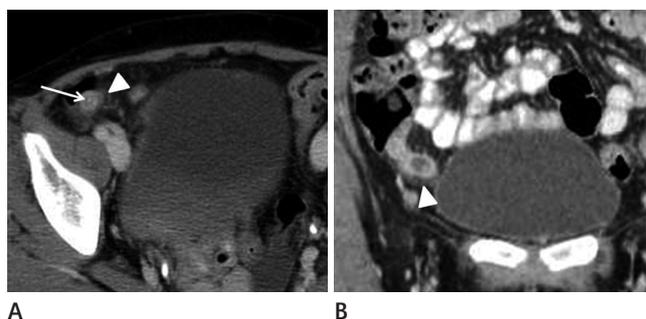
Computed tomography (CT) findings of fibrous obliteration in the appendix of a 43-year-old woman. A. Axial CT scan shows periappendiceal infiltration (arrowhead) and a linear-enhancing core structure (arrow). B. Coronal CT scan shows periappendiceal infiltration (arrowhead). Note the thickened appendiceal wall and dilated lumen.
